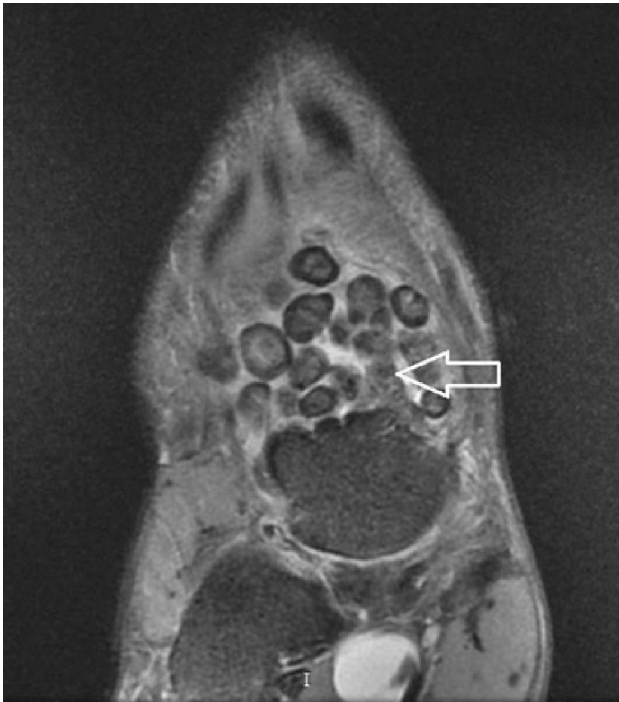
MRI (Axial PD fat saturated image) of right ankle joint showing no loss of signal in loose bodies.
